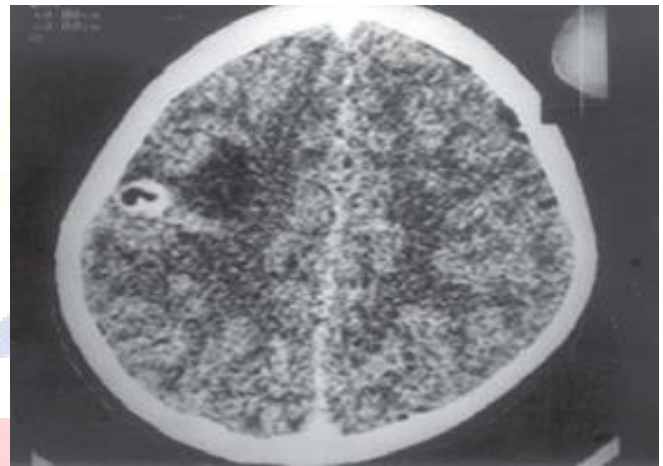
Contrast-enhanced cranial CT scan showing a single enhancing lesion.
